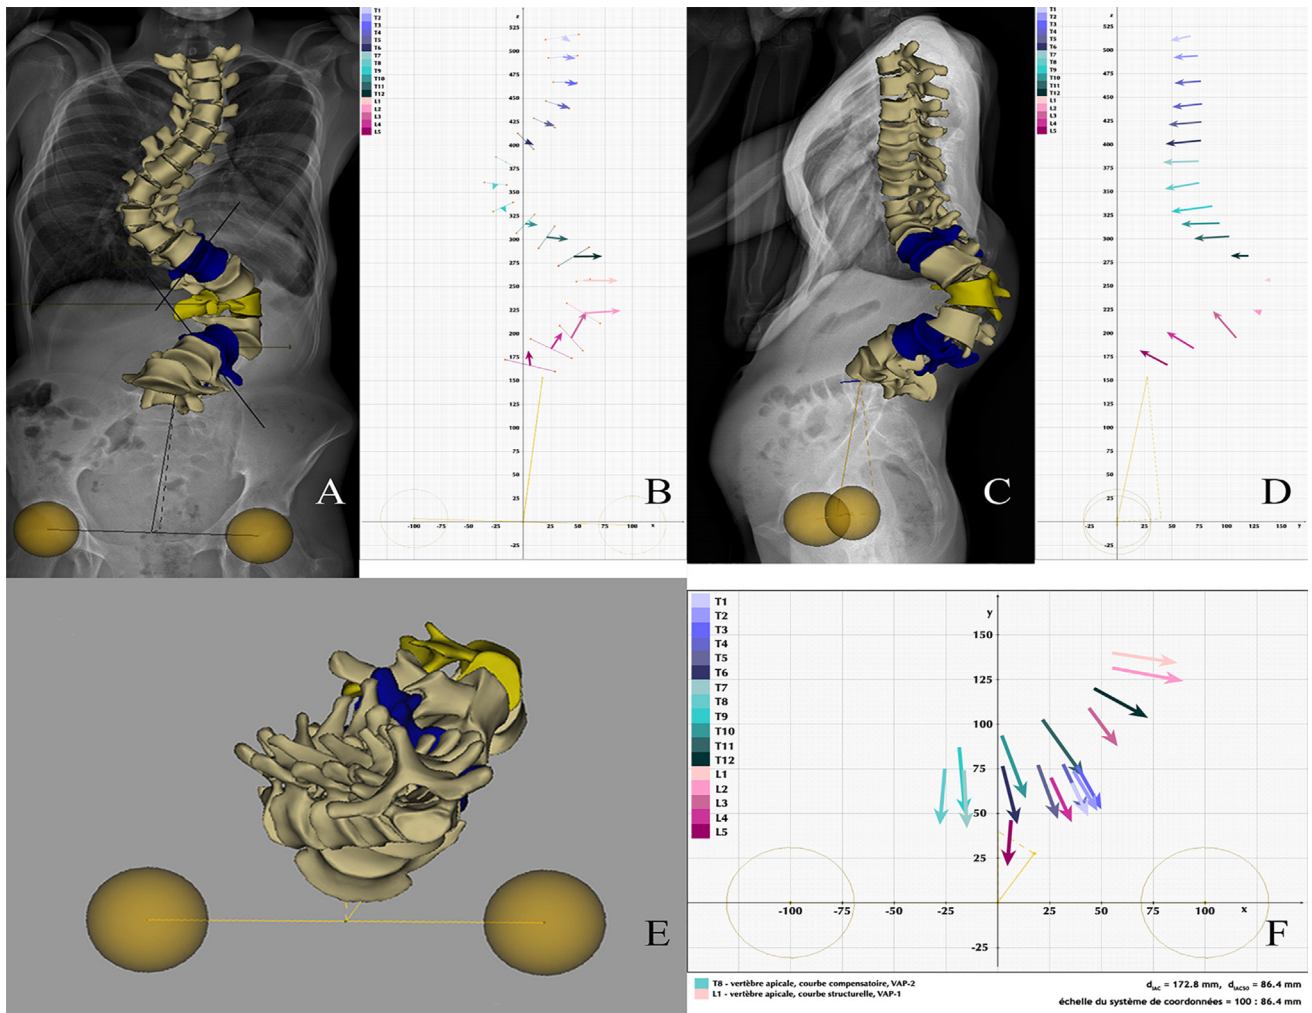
2D/3D EOS and the use of vertebral vectors to visualise severe scoliosis. A. 3D reconstruction on a postero-anterior radiograph. B. The vertebrae have been replaced by their vertebral vectors. With vertebral vector visualisation in the coronal plane, only the small arrows representing the terminal parts of the vectors are visible for the vertebrae that have no axial rotation (T7 and T8). With increasing vertebral rotation, the projection of the vectors becomes more visible, until the arrows seem to represent the full length of the vectors, indicating nearly 90° of rotation (L1 and L2). Decomensation of the upper part of the body can also be determined from the distance between T1 and the Z axis. The magnitude of the coronal curve is directly proportional to the X axis coordinates of the vertebral vector. C and D. Lateral radiograph with 3D reconstruction (C) and visualisation using vertebral vectors (D). In the sagittal plane, most of the vectors are visible along their full length, clearly delineating the sagittal spinal curves. As axial rotation increases, the projected vector lengths decrease continuously; when rotation reaches 90°, only the arrowheads are visible (L1 and L2). E and F. 3D reconstruction in the axial plane (E) and visualisation of the vertebral vector (F). In the axial plane, vertebral rotation does not affect the projected length of the vectors. Thus, the angle related to the Y axis shows the projected axial vertebral rotations. The X axis coordinates measured in the axial plane are directly proportional to the amount of lateral vertebral translation [42].
